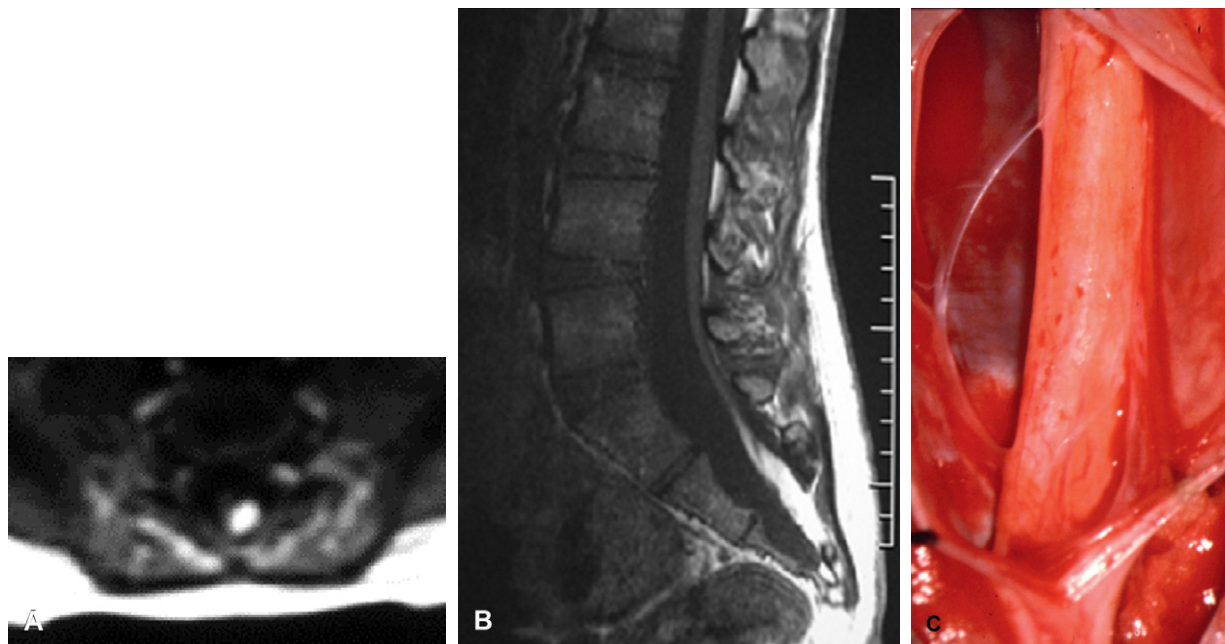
Lipoma of the filum. (A) T1-weighted axial MR; (B) T1-weighted sagittal MR; (C) surgical view.
